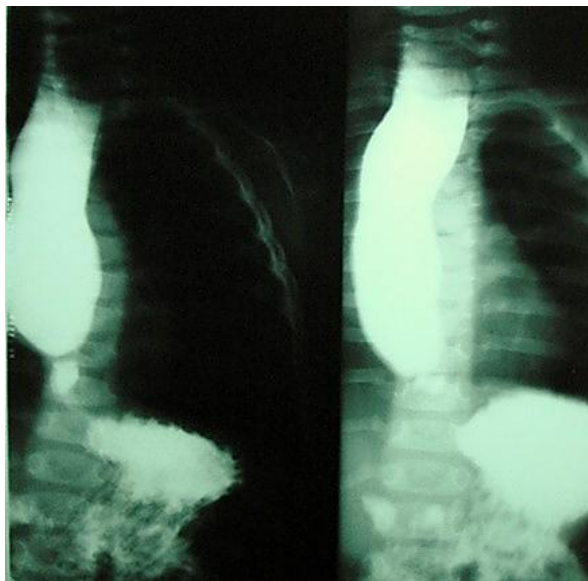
A per-oral contrast agent-supported chest X-ray showed filiform stenosis of the lower third of the esophagus.
